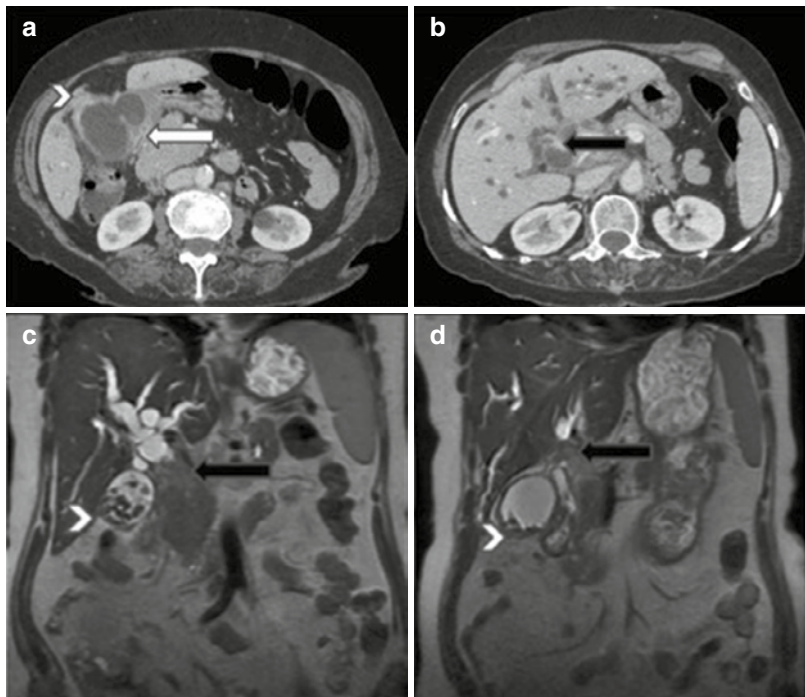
A case of a locally advanced carcinoma of the gallbladder: (a, b) Contrast-enhanced axial CT and (c, d) coronal T2W MR images reveal diffuse asymmetric circumferential mural thickening of the gallbladder (white arrows) with adjacent hepatic (arrowhead) and duodenal infiltration (white arrow) and contiguous extension along the cystic duct to involve the proximal third of the common duct (black arrow) and resultant upstream biliary dilatation
